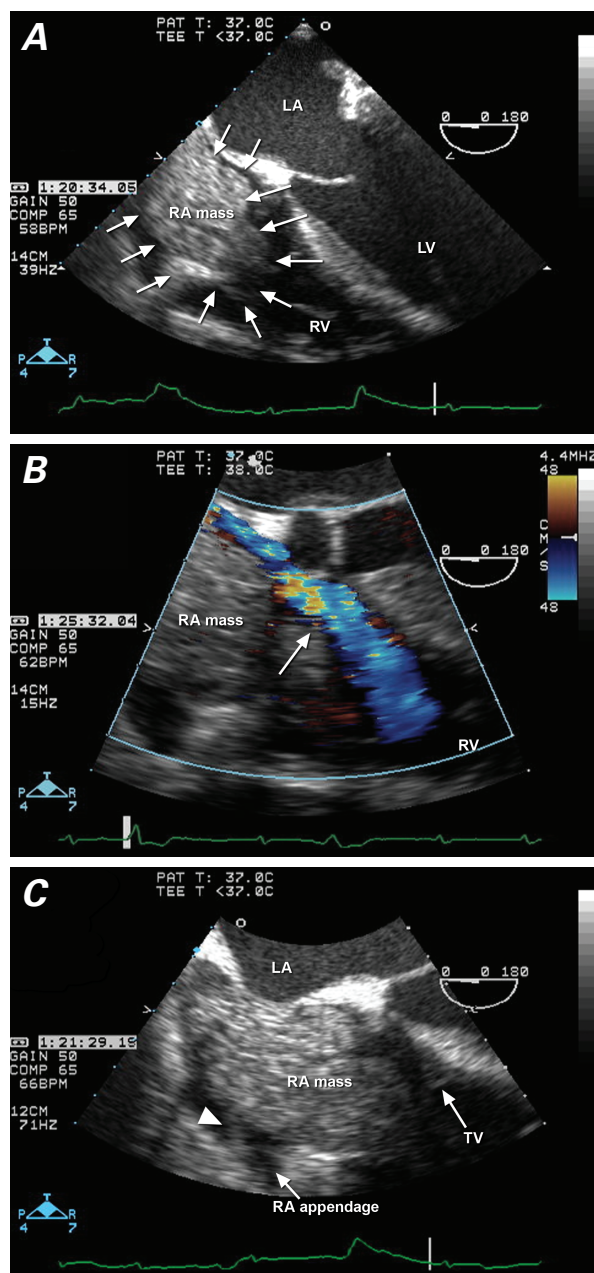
Transesophageal echocardiography in a patient with superior vena cava syndrome shows A) a mass filling the entire right atrium (RA) and protruding through the tricuspid valve (4-chamber view); B) restricted venous return (arrow) around the RA mass into the right ventricle (RV) (color-flow Doppler), and C) attachment by pedicle (arrowhead) of the RA mass to the RA free wall.
